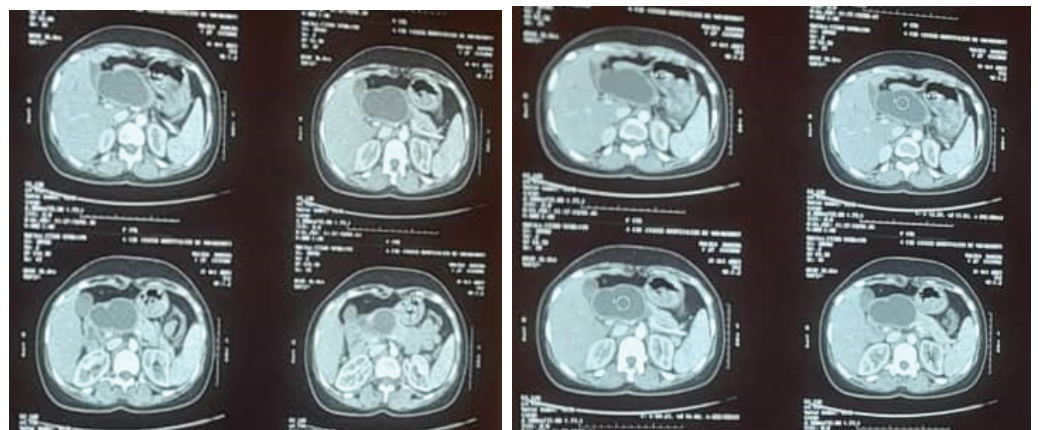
Abdominal CT scan: axial slices showing a cystic formation located in the head and body of the pancreas
